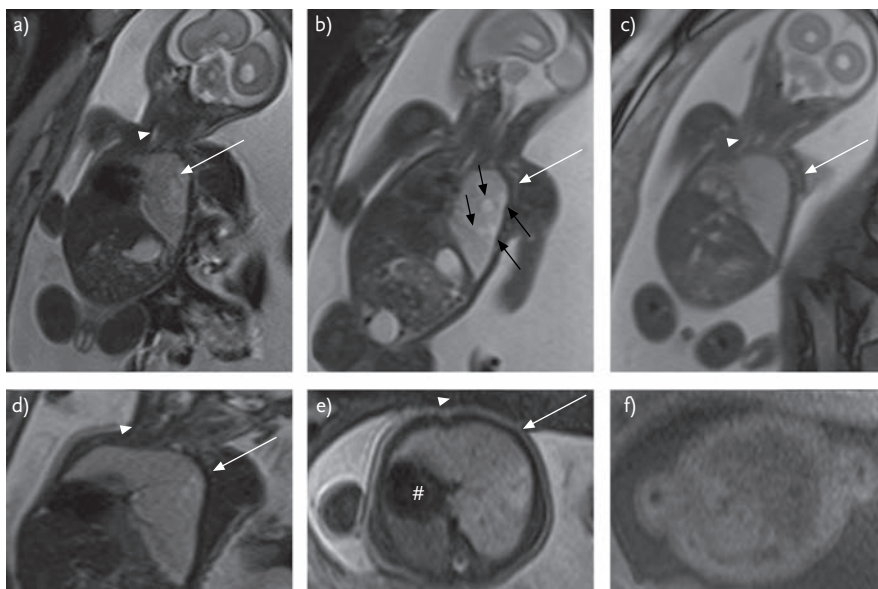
A fetus at 23 months +4 days of gestation. a–e) Hyperinflation of the left lung (arrows) associated with trans mediastinal hernia (arrowheads) and right mediastinal shift (#). Many centimetric lesions are present in the pulmonary parenchyma (black arrows). f) These lesions are hyperintense in T2- and hypointense in T1-weighted fat saturation images, indicating cystic lesions suggestive of a Type II CPAM (Stocker classification).
